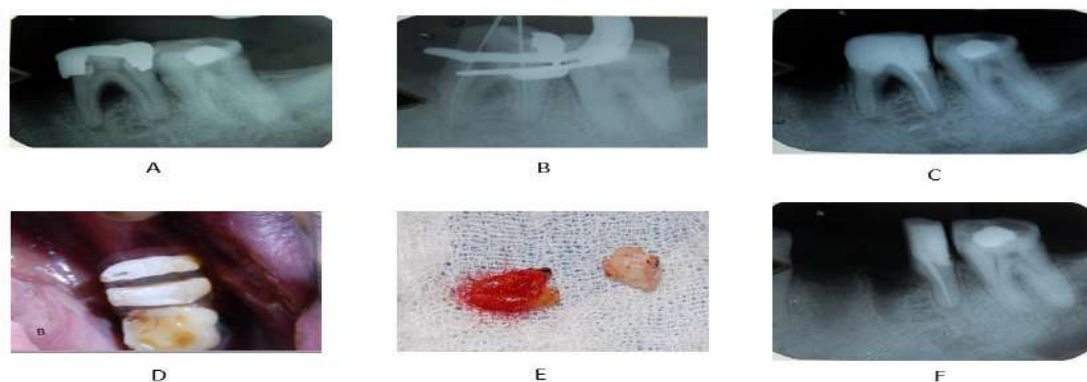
A) Radiograph showing vertical bone loss around mesial B) working length determination C) obturation of only distal root D) Vertical cut towards the bifurcation E) Amputation of mesial half F) Radiograph showing retained distal portion
